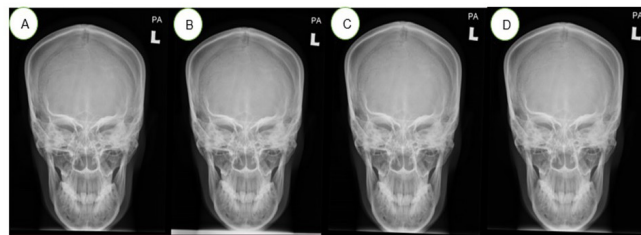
Image of OF10° skull radiograph obtained at different SID with A= 100cm, B= 110cm, C=120cm, and D=130cm, were assessed for Criteria 1, 2, 3, and 4 and scored according to VGA scoring.
